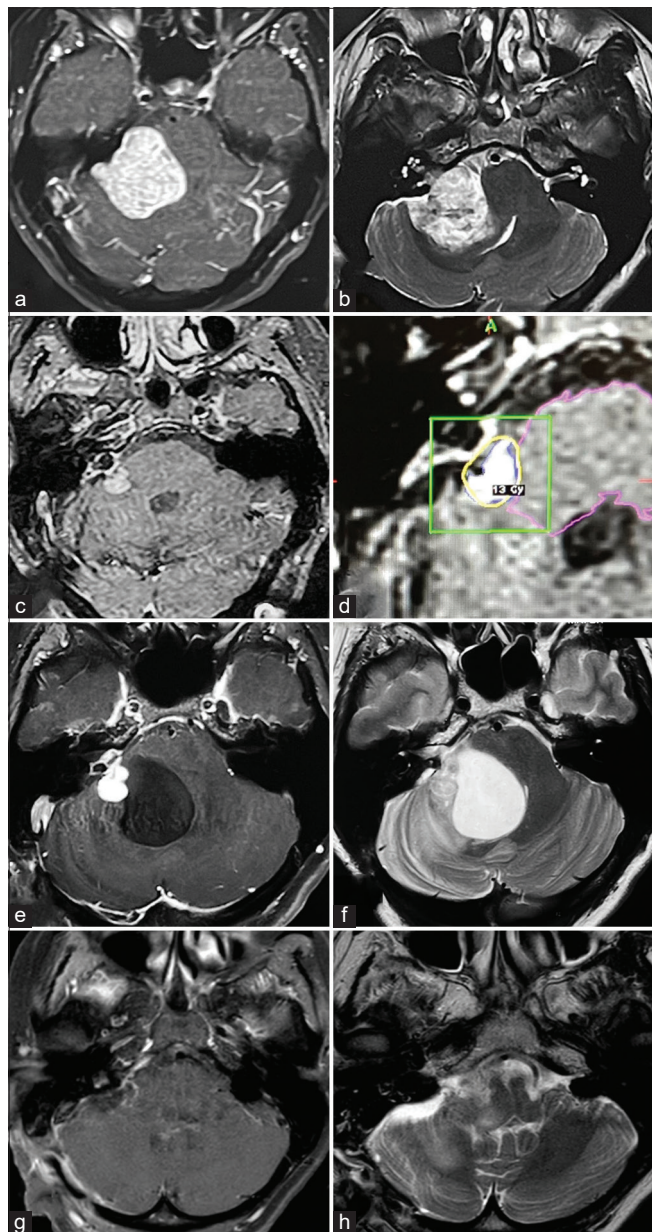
Magnetic resonance imaging at diagnosis is showing in contrast enhanced T1- (a) and T2-weighted (b) axial sequences a contrast-enhancing extra-axial lesion in the right cerebellopontine angle with significant brainstem compression. Subtotal resection (c) due to brainstem adherence revealed the diagnosis of a vestibular schwannoma. Gamma Knife radiosurgery was performed (d) with 13 Gy at 50% isodose. Two and a half years following radiosurgery, the patient presented with imbalance while walking. Contrast-enhanced T1- (e) and T2-weighted (f) axial sequences shows formation of a large extratumoral non-enhancing cyst. The cyst was decompressed and tumor near-totally resected (g and h) under facial monitoring, resulting in complete neurological recovery.
